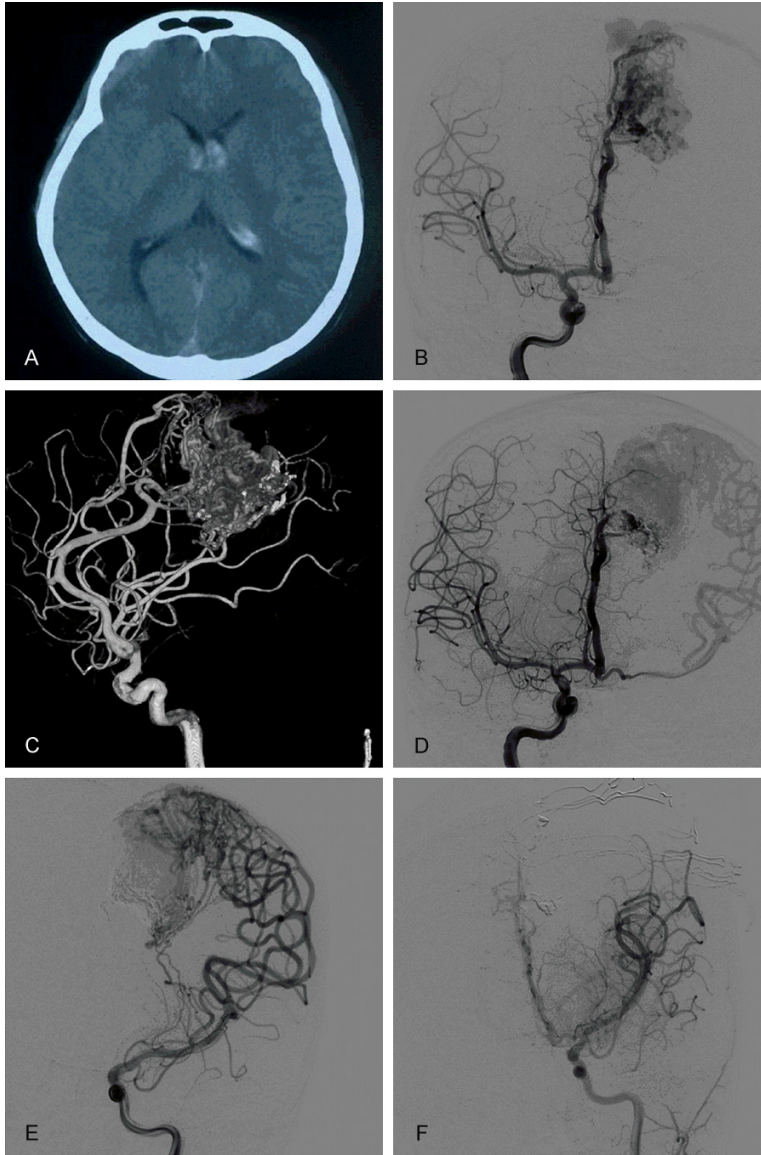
Images from case 3. A: Head CT shows bilateral ventricle hemorrhages that are greater on the left side; B: Right internal carotid artery DSA shows that the AVM was supplied by the distal end of the left ACA and that the AVM was located in the left frontal and parietal lobes; C: 3D-DSA shows 2 aneurysms on the genu of the corpus callosum of the left ACA; D: Embolization of the AVM with Onyx via the ACA and DSA showing a reduction of the AVM volume; E: Left MCA angiography shows part of the AVM located laterally, which was supplied by the cortex of the MCA, and the wedge lenticulostriate artery also participated in the blood supply; an aneurysm is shown at the end of the lenticulostriate artery, which was part of the AVM that was not embolized; F: DSA shows total resection of the AVM after embolization of the medial AVM.
